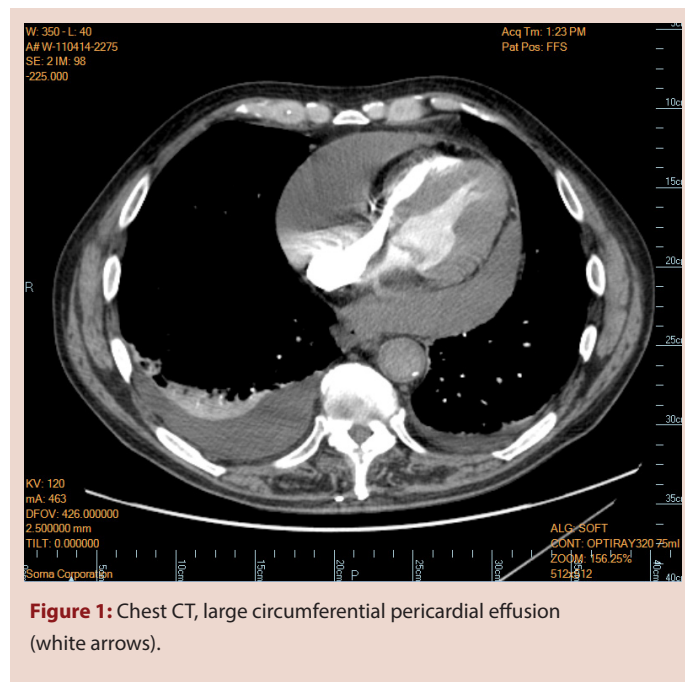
Chest CT, large circumferential pericardial effusion (white arrows).
